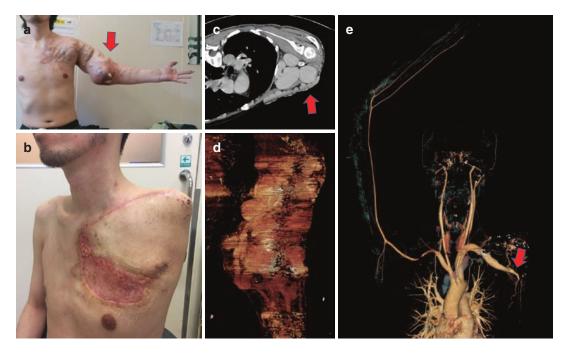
CC: pulsating mass on left forearm and chest wall. Dx: Arteriovenous malformation. (a) preop picture. (b) post op picture: left arm disarticulation. (c and d) preop CTA. (e) postop CAT
